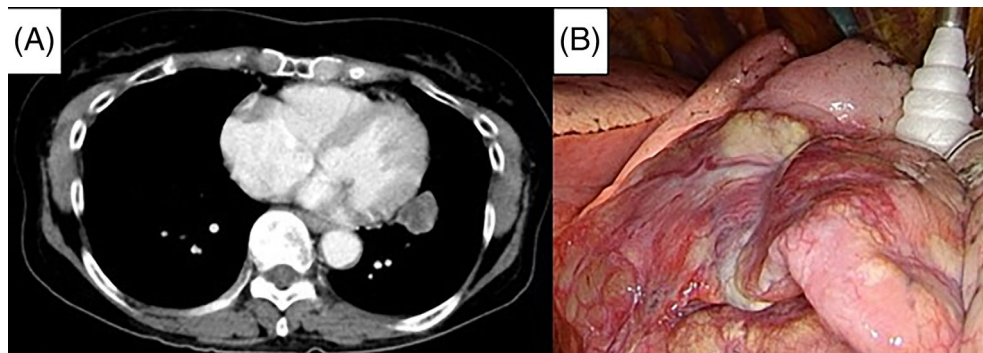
(A) Contrast CT scan. A $45 \times 30 \times 22$ mm large mass with slightly irregular margins was observed in S8 of the left lung. The interior was a mixture of cyst-like hypodense areas and hyperdense areas that were thought to be substantial components. (B) Intraoperative image. A white mass with indistinct margins was found in the lower lobe of the left lung. There was no pleural effusion, exposure to the pleura, or pleural seeding
